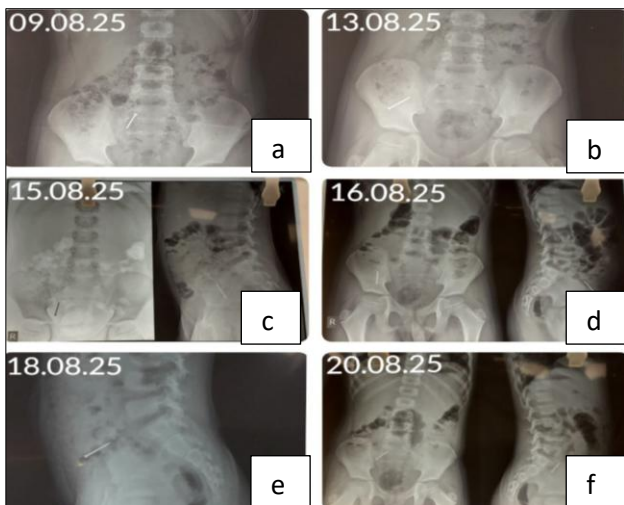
(a-f): Serial abdominal X-rays.
